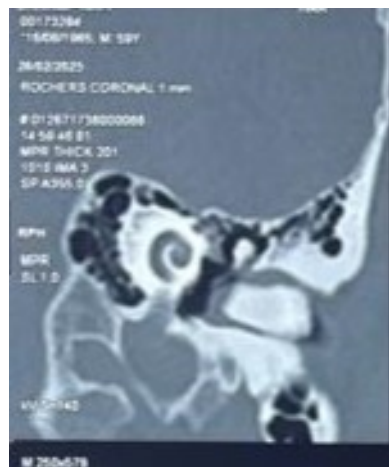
Non-injected CT scan of the temporal bone (coronal section) showing an obstruction of the left external auditory canal by a radio-opaque material that was not adherent to the skin lining of the canal. The relief of the tympanic membrane appeared to be respected.
